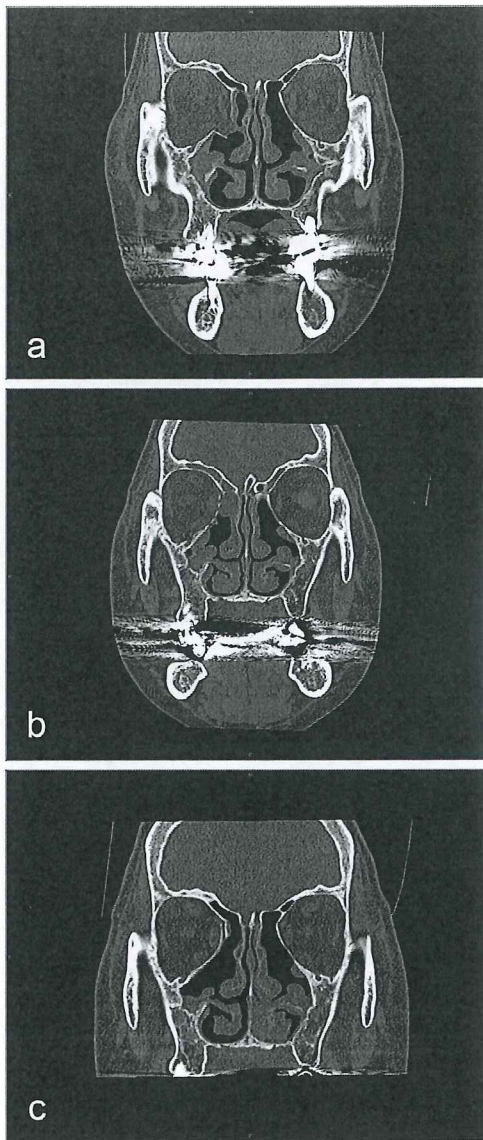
Coronal computed tomography findings in a 62-year woman with orbital wall fracture caused by a fall. a, Preoperatively, the right orbital floor and medial wall fracture and soft tissue herniation with a bony are seen. b, Immediately after the operation, the orbital floor and medial wall were satisfactorily reduced with the u-HA/PLLA sheet. c, Forty-seven months after the operation, the curve and the location of the implant were satisfactory.
